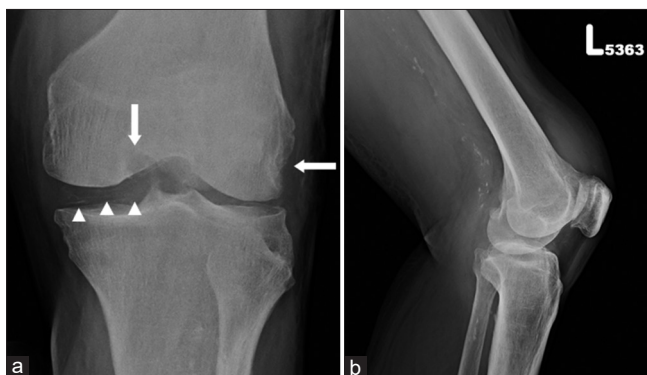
X-ray of the patient's affected left knee, (a) Coronal view. Joint space narrowing at the lateral aspect of the knee. Chondrocalcinosis at the medial joint space (arrowhead). Bone erosions were discovered at the lateral femur and the lateral border of medial femur condyle. (arrow), (b) Sagittal view. Increased suprapatellar bursal effusions and periarticular soft-tissue and subcutaneous swelling were seen. Calcification in popliteal artery identified
